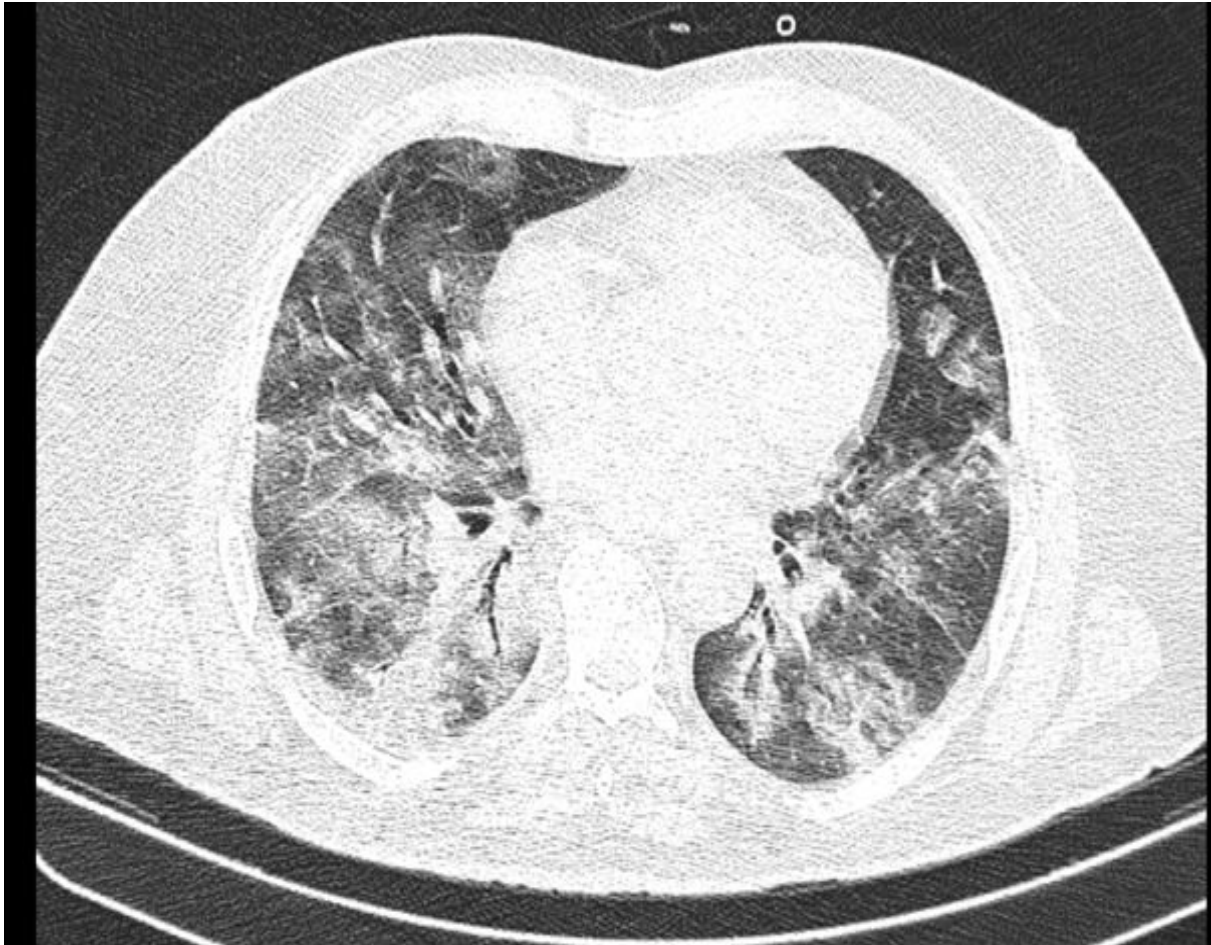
CT chest shows consolidation with air bronchogram
